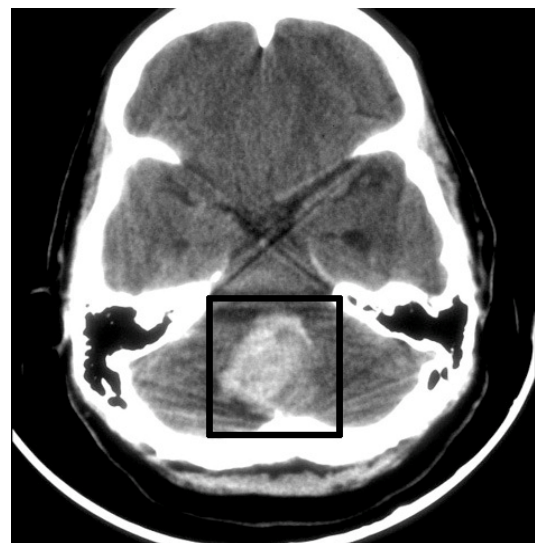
Intracerebellar hematoma – CT screening
